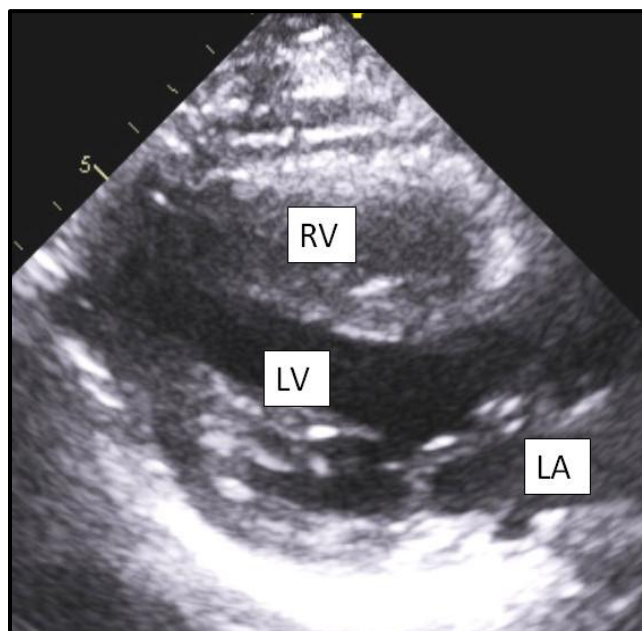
Echocardiogram, LVEF= 35-40%. (Abbreviations as in Figure 2).
